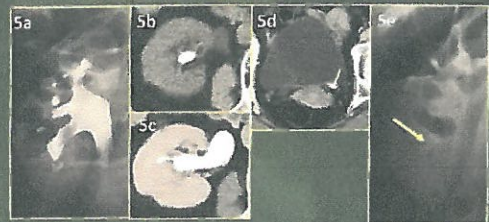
Mimicking right lower fundibulum stone as UC. (a) 5 minutes RP shows a filling defect at right lower calyx and fundibulum. (b) The initial scan shows a mass in right fundibulum. (c) The CT of the same portion showing no evidence of the above mass. Inverse performing a CT urography with contrast filling the portion of urinary duct. We realized the location of the central & center of CT urography during the RP image. (d) A filling defect shows CT scan shows the left distal end ureter (yellow arrow). (e) Retrospectively review the left UVP scan image shows a faint retrograde stone at the same location of the right lower fundibulum.
